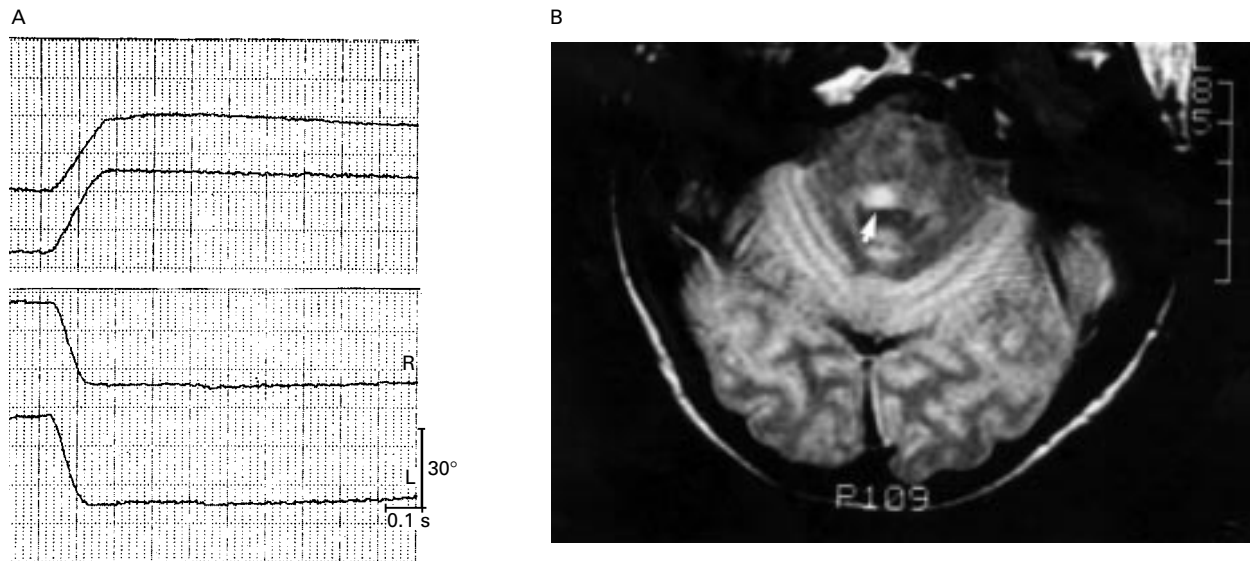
(A) Slowed saccades to the right (upward deflection; right eye: 247/s, left eye: 271°/s) and normal saccades to the left (downward deflection; right eye 448°/s, left eye 422°/s) in patient 33 with right sided vestibular paresis due to pontine ischaemia. (R=right eye; L=left eye). (B) T2 weighted MRI of the same diabetic woman documenting an ipsilateral pontine lesion compatible with infarction, which involved the region of the medial vestibular nucleus and the paramedian pontine reticular formation.
